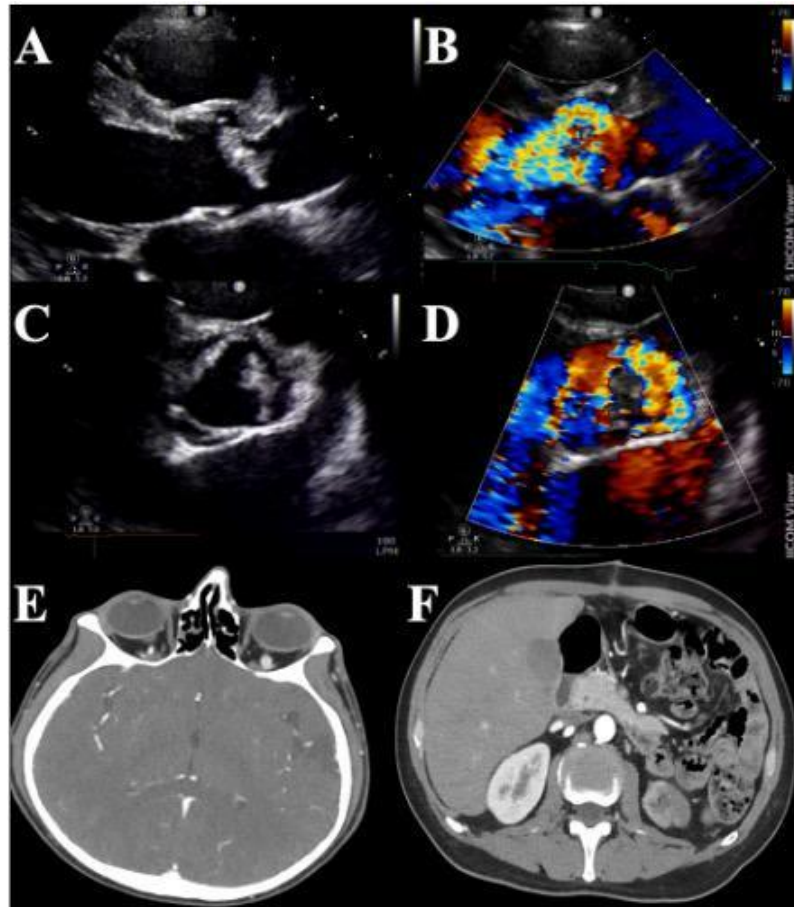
A) Transthoracic echocardiogram parasternal view that shows an oscillating mass in ventricular face of the aortic valve. B) Color Doppler in parasternal view, showing severe aortic regurgitation. C) Transthoracic echocardiogram parasternal short axis view reveals a mass on the right and left leaflets of the aortic valve, as well as the presence of aortic annular abscess. D) Color Doppler shows aortic insufficiency and annular abscess. E) Brain CT scan axial view. Cortical hypodensity at the left temporal-occipital pore. F) Abdominal CT scan axial view. Evidence of left renal infarction in the middle third towards the lateral surface, thrombosis of left renal artery, splenic abscess and partial thrombosis of celiac trunk and splenic artery.
